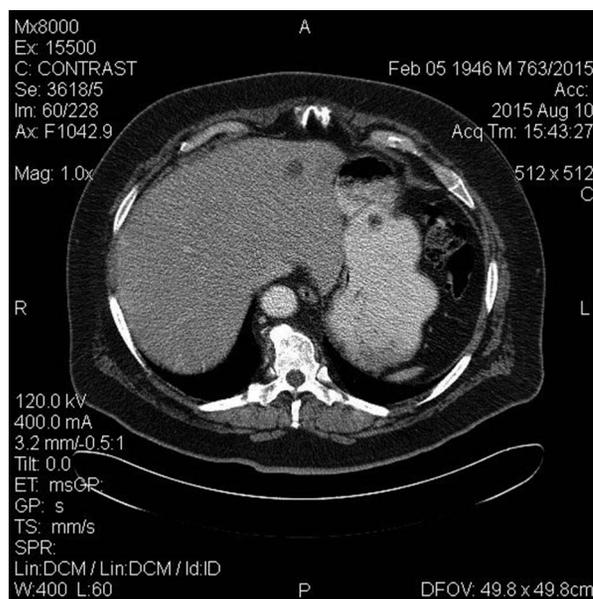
Computed tomography: Axial arterial phase tomogram. An oval heterogeneous hypodense lesion in the left liver lobe with contrast enhancement
